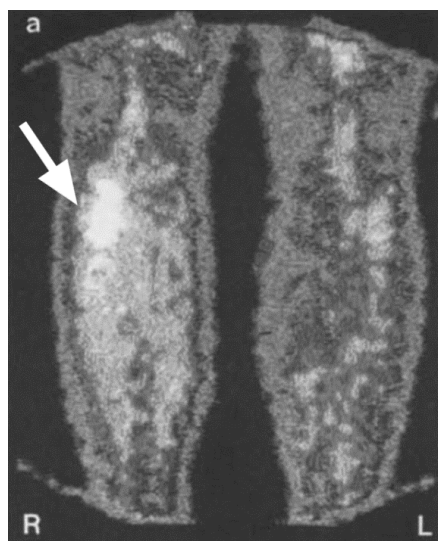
^{99m}Tc -plasmin scintigraphy of knee and calf region. Right leg (R) knee region signal (arrow) is higher than in corresponding region of the left leg (L), indicating DVT. Reprinted from Dahlborn and coworkers with kind permission from Springer Science and Business Media.⁸¹
